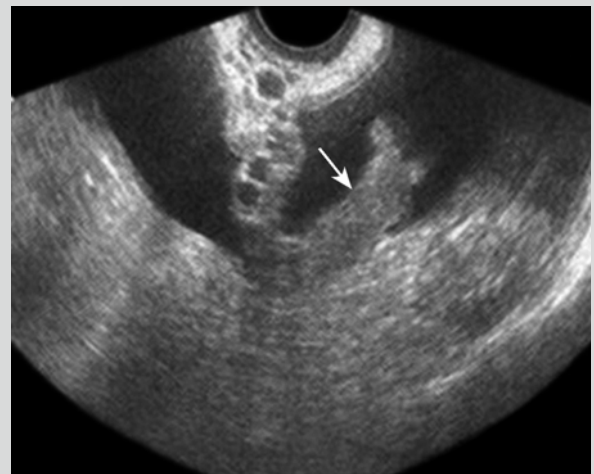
Pelvic inflammation. Ultrasound finding of pelvic fluid and thickening of oviduct (indicated by arrow)
